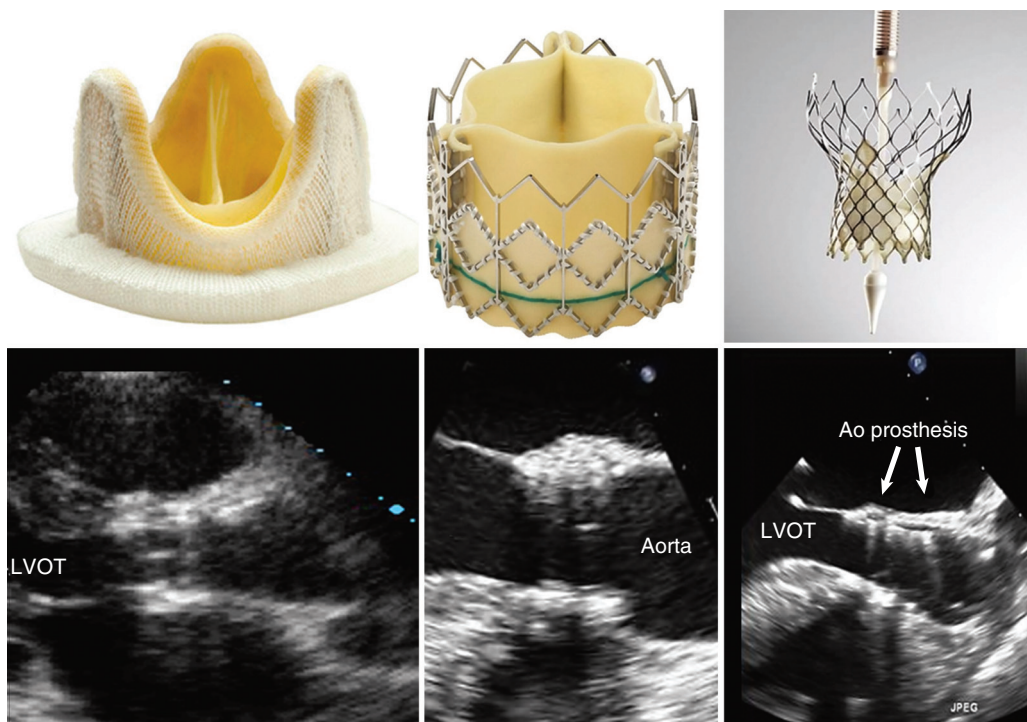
Bioprotheses and their echocardiographic long-axis appearance when implanted in the aortic (Ao) position. Left panels, Heterograft stented bioprosthesis. Middle panels, Sapien balloon expandable transcatheter aortic valve. Right panels, CoreValve self-expanding transcatheter aortic valve.
